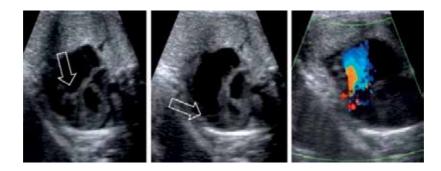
Ebstein's anomaly. The arrow indicates the dysplastic tricuspid valve with septal and posterior leaflets of the tricuspid valve displaced toward the apex of the right ventricle. Color Doppler investigation shows significant valvular regurgitation.
